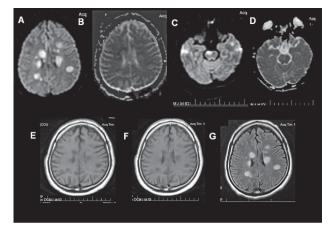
Axial diffusion weighted images(DWI) of Brain (A) and (C) showing multiple nodular lesions of diffusion restriction in bilateral parietal periventricular and subcortical regions, corresponding ADC images (B)
